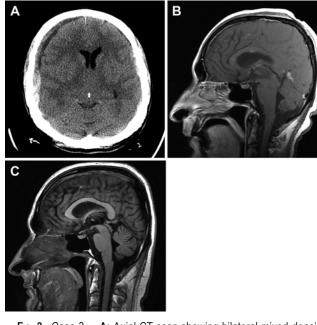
Case 3. A: Axial CT scan showing bilateral mixed-density subdural fluid collection (rt > lt) with mild (2-mm) midline shift. B: Midline sagittal T1-weighted MRI study obtained after addition of contrast material showing flattening of the pons against the clivus and descent of the midbrain characteristic of intracranial hypotension. C: Midline sagittal T1-weighted FLAIR MRI study showing resolution of intracranial hypotension findings, with a wider prepontine cistern at the 4-month follow-up visit.
